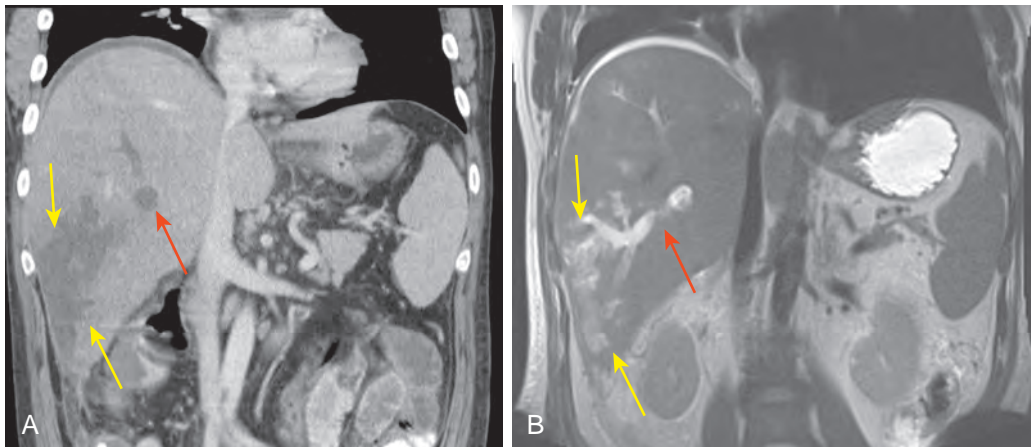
Septic intrahepatic portal vein thrombosis: CT and MR findings. Coronal CT (A) and MR (B) reformatted images show thrombus (red arrow) within an intrahepatic right portal vein. Infection in the liver (yellow arrows) peripheral to this infected thrombus is also present. There is a small amount of ascites.
